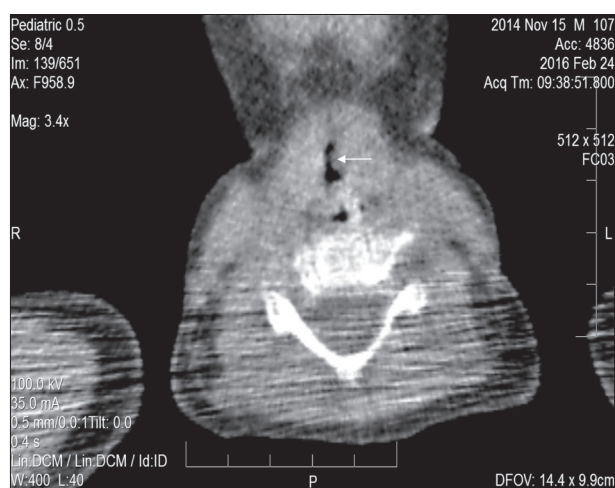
The multidetector computed tomography at the level of C2–3 vertebral body of the 15-month-old boy (4th hospitalization day) – on the left airway wall (arrow) discovered thickening/hypodense/polypoid change which narrowed asymmetrically the lumen of the border larynx/trachea to the smallest diameter of 2 mm
